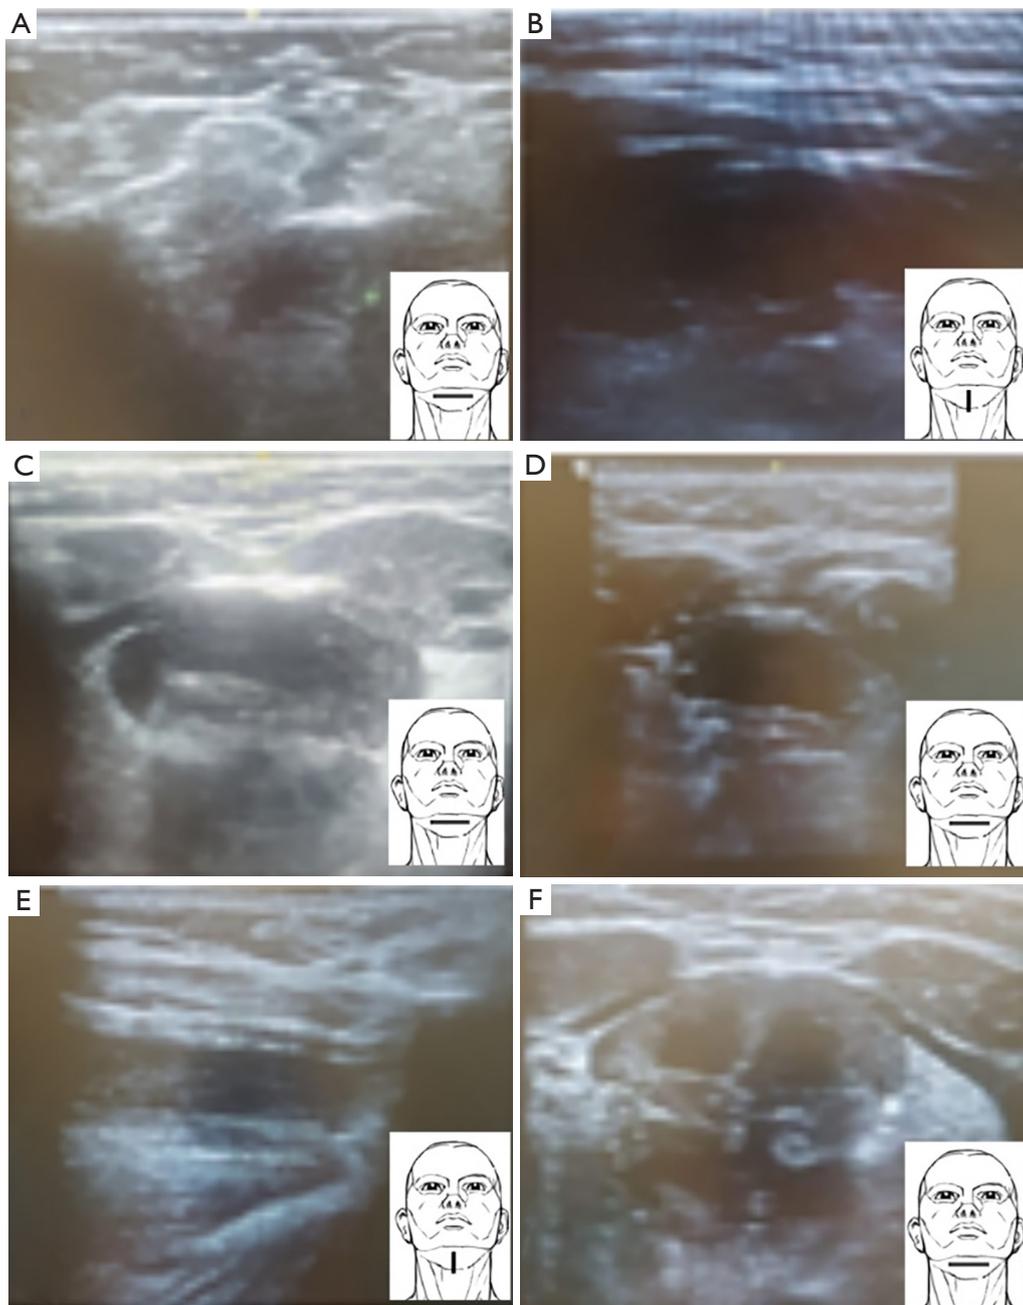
Different ultrasound pictures of the submental area, the positioning of the probe is shown on the right lower corner of each picture, they were classified according to semi-quantitative score. (A) and (B) are scored as '0' due to inaccurate positioning of the probe (not centralized), improper view not showing the required structures, (C) and (D) are scored as '1', as they hardly show the lower margins. (E) and (F) are scored as '2', with good quality, unblurred vision showing the required structures adequately with proper positioning of the probe.
